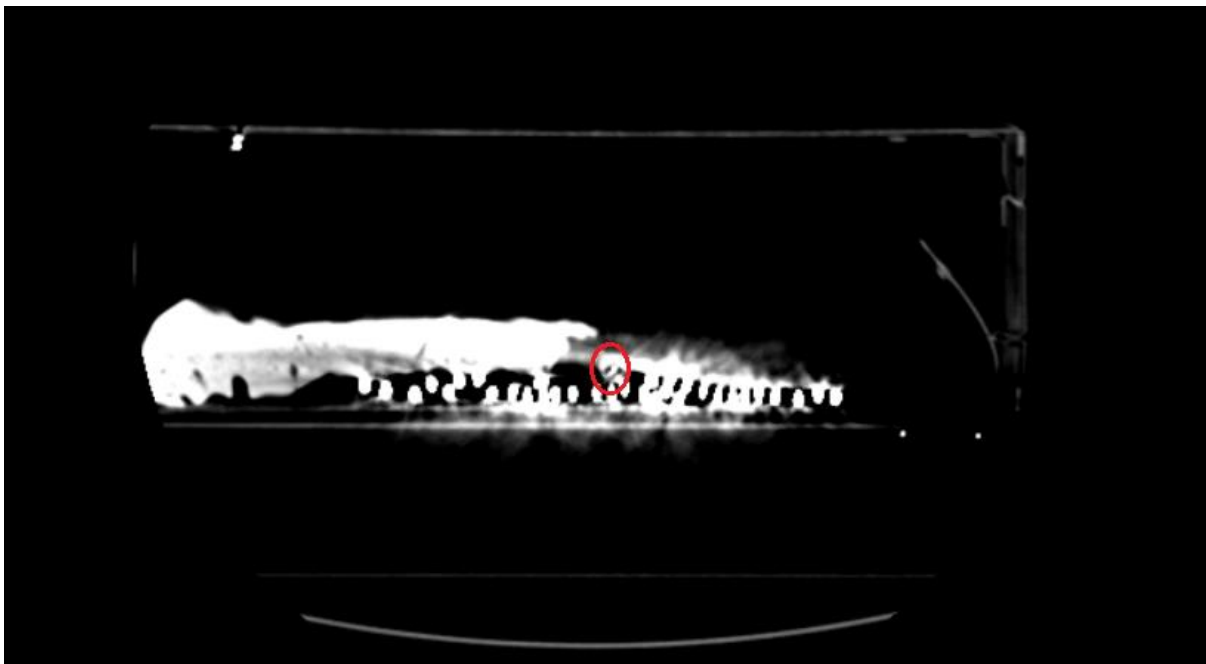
A cross section of the briefcase using the CT scanner, circled in red is a cross section of the detonator.
